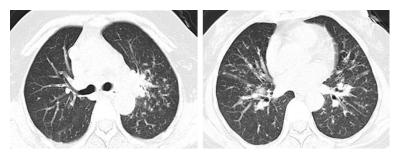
The CT scan images show thatthe swollen mediastinal lymph nodes remained the same as before, but pleural effusion did not relapse afterthe anti-tuberculosis treatment for 9 months.
